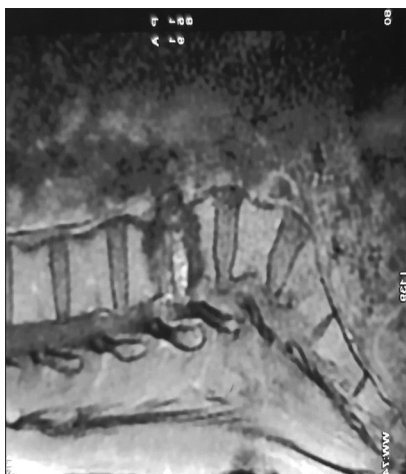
Magnetic resonance imaging sagittal view of the lumbosacral region distortion of the L3 and L5 showing wedged collapse of the L3 and L4 with herniation of the disc content causing severe canal stenosis
